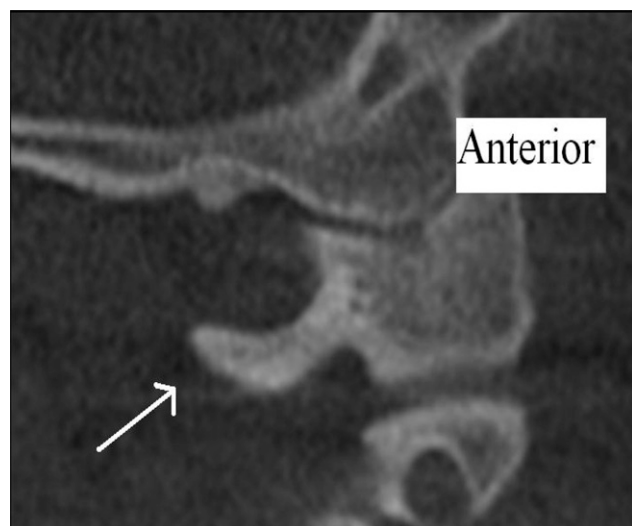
Cone beam CT sagittal section of an atlas without ponticulus posticus (Class 1) in a 16-year-old black female. The arrow indicates a normal segment of the posterior arch.
